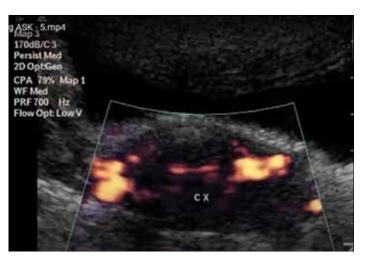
The figure shows TV color doppler of the CA cervix vascularity
